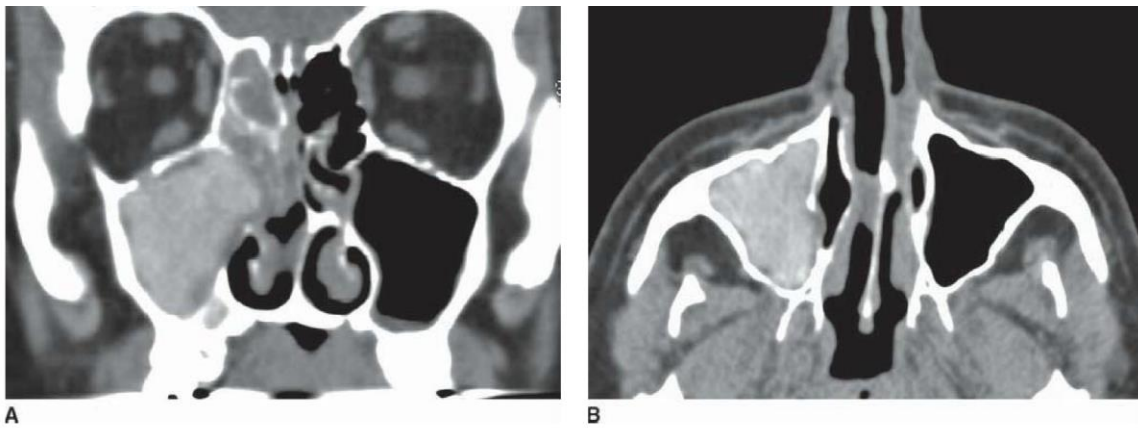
A,B: Fungus ball of the paranasal sinuses axial and coronal noncontrast CT scans show complete opacification of the right maxillary sinus, higher attenuation densities within the sinus, and thickening of the paranasal sinus mucosa consistent with chronic inflammation. Image and caption: Jeffrey Bennett, MD. Department of Radiology, University of Florida College of Medicine, Gainesville, FL.
